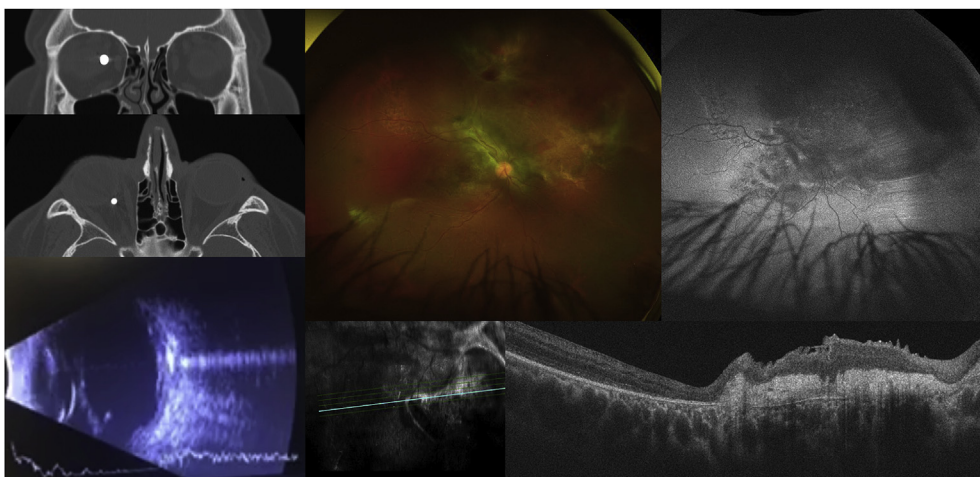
A 17-year-old male was assaulted on his way home from school with a BB gun. Computed tomography scan demonstrated the BB located within the orbit at the posterior margin of the globe (Top left, Middle left). B-scan ultrasonography shows layered vitreous hemorrhage in posterior pole and hyperechogenicity of the BB (Bottom left). Optos ultra wide-field imaging showed macula-involving commotio retinae, a fibroglial scar with sharp serrated borders superiorly, and an adjacent localized retinal detachment (Top middle). Fundus autofluorescence showed hypoautofluorescence within the area of choroidal rupture (Top right). Optical coherence tomography showed a rupture through the choroid, retinal pigmented epithelium and outer retina consistent with sclopetaria (Bottom right).
